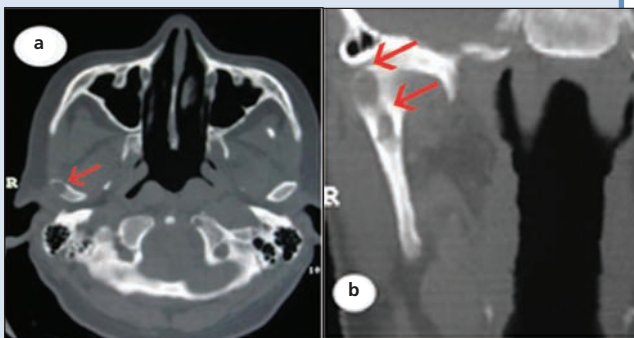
Axial (a) and coronal (b) CT scans showing the lesion in the right condyle.
